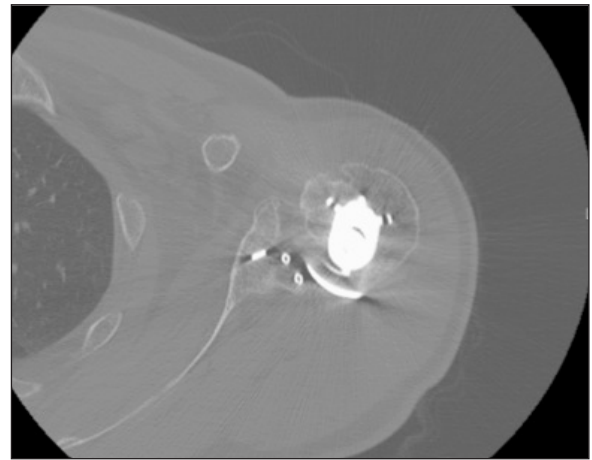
Axial computed tomography scan showing orientation of screws relative to intact central peg of glenoid component
